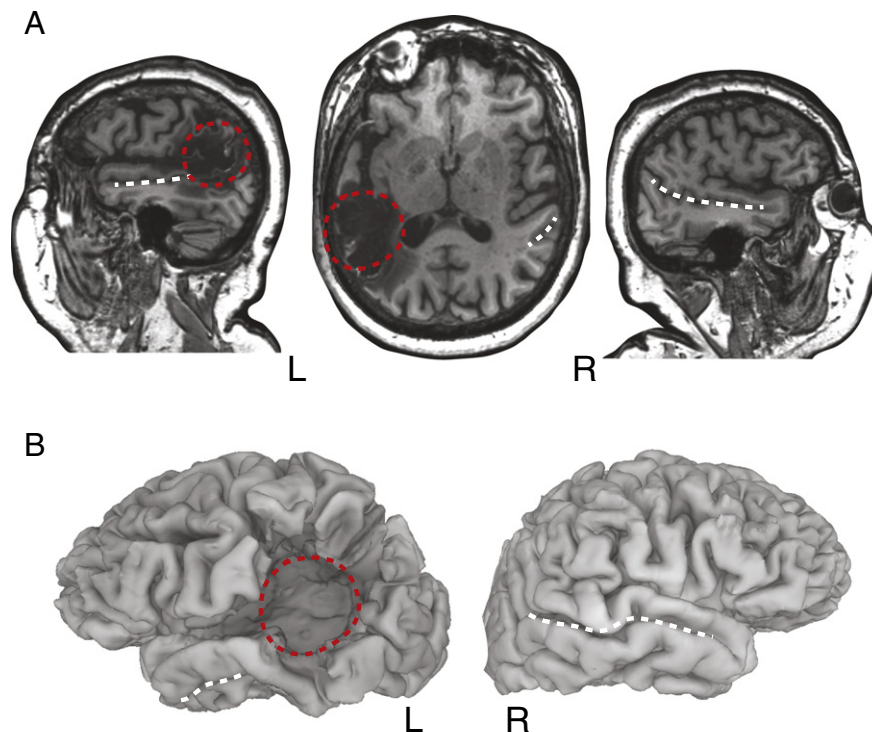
Anatomical MRI of SJ. A. Sagittal and axial slices of SJ's structural MRI. White dashed lines indicate the location of the STS. Red dashed circle indicates stroke-damaged cortex in left hemisphere (left is left on all images). B. Cortical surface reconstruction of SJ's brain from the structural MRI.
